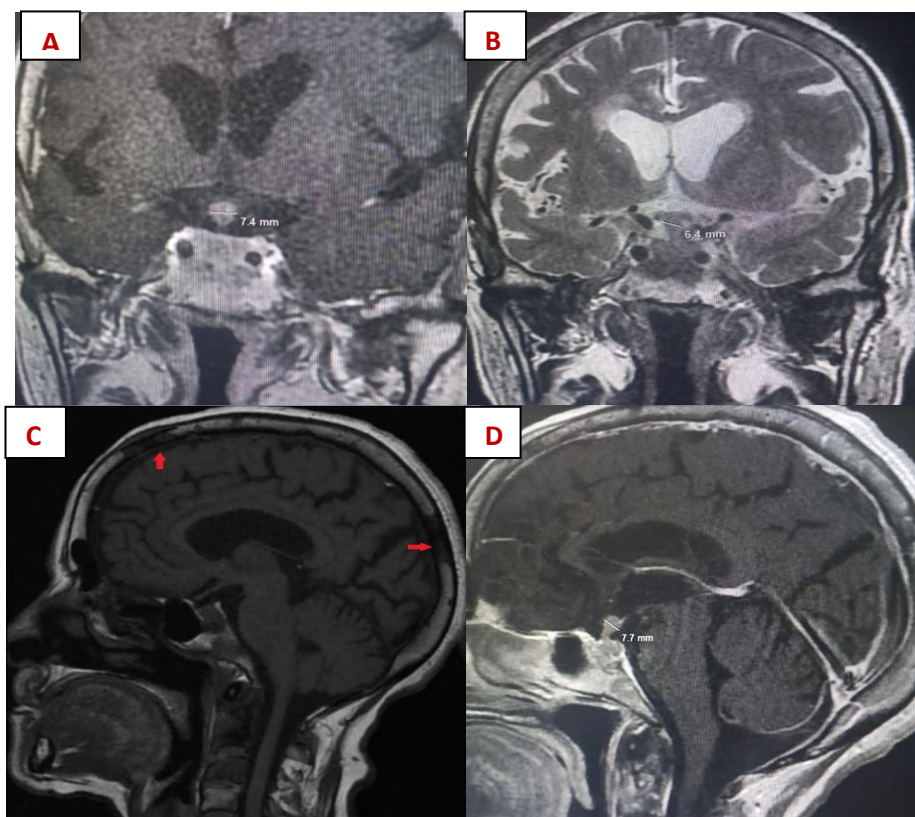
Coronal (A,B) and Sagittal (C,D) MRI showed nodular thickening of the pituitary stalk, hypertrophy of the pituitary gland and absence of visualization of the posterior pituitary Multifocal meningeal thickening, right frontal and temporal and irregular left posterior parietal repulsed after injection of the contrast medium
